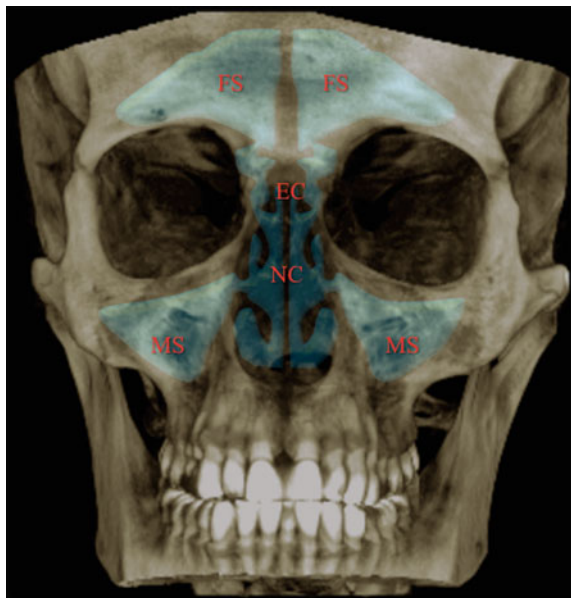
Graphical raffiguration of paranasal sinuses on a CBCT-3D reconstruction of the splanchnocranium: frontal view. *MS* maxillary sinuses, *EC* ethmoidal cells, *NC* nasal cavity, *FS* frontal sinuses
